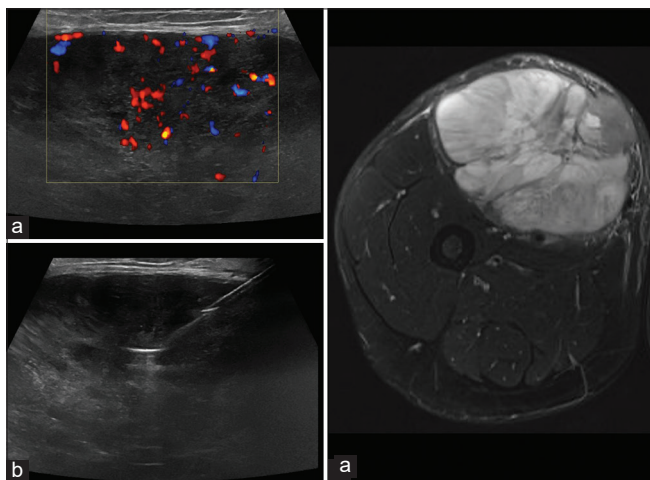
True discrepant lesion with a diagnosis of Grade 1 spindle cell sarcoma on core biopsy and Grade 3 fibromyxosarcoma following surgical excision. (a) Ultrasound demonstrates a hypervascular and heterogeneously hypoechoic mass in the right thigh. (b) Ultrasound image depicting 16-gauge core biopsy needle within the lesion (3 cores obtained). Axial STIR MRI (c) shows an aggressive mass centered on the sartorius muscle displacing the femoral neurovascular bundle.
